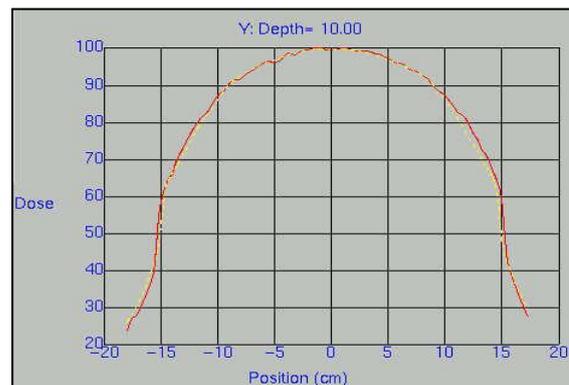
Measured and calculated Inplane Profile for the CBCT dose calculation model
